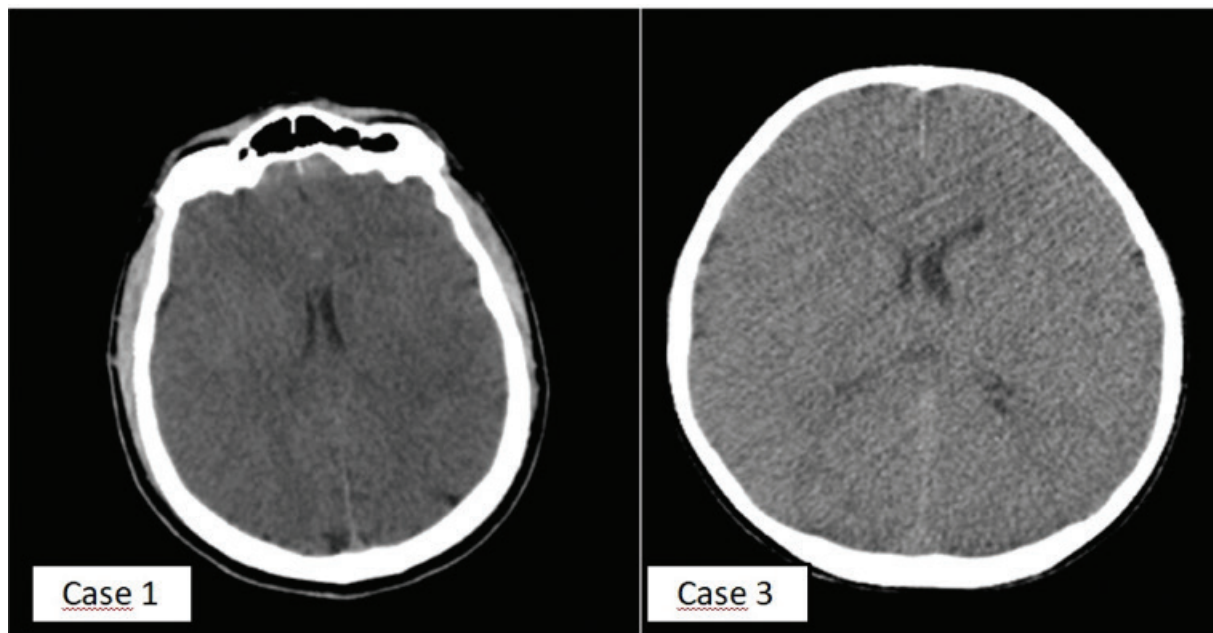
Brain computed tomography images of the two cases presented to the emergency department due to near-drowning.
